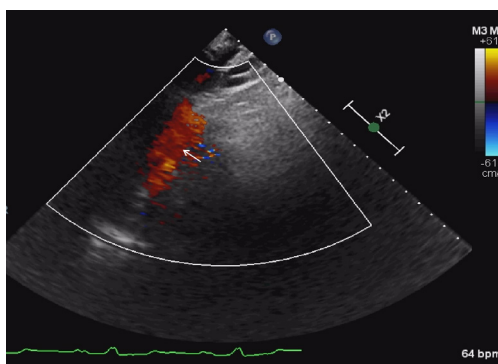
CDFI: a suprasternal fossa view of the heart showing the vertical vein with an upward flow. The arrow shows the blood flow of the ascending vertical vein. CDFI, color Doppler flow imaging.
